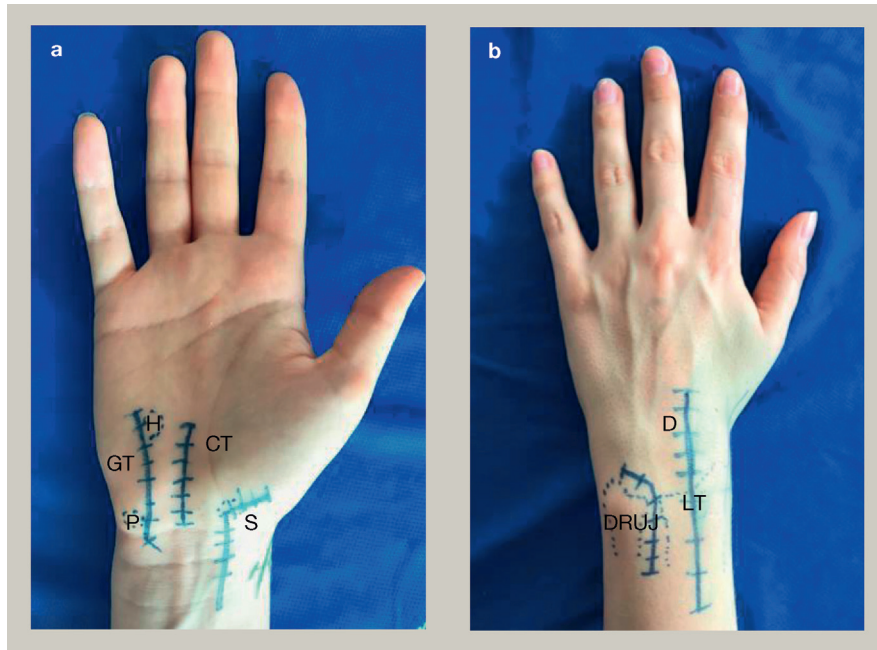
Skin marking of the volar and dorsal approaches. (a) Volar approaches. (b) Dorsal approaches. CT, carpal tunnel incision; D, dorsal incision; DRUJ, distal radioulnar joint; GT, Guyon's canal incision; H, hook of hamate; LT, Lister's tubercle; P, pisiform; S, scaphoid volar approach.
